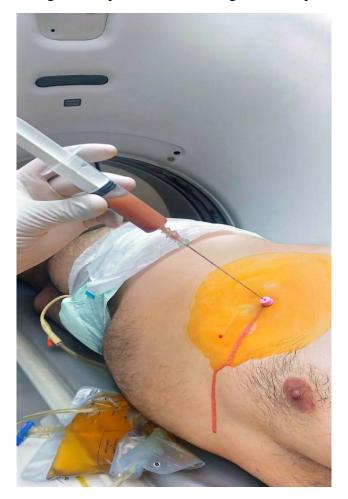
CT-guided aspiration puncture
